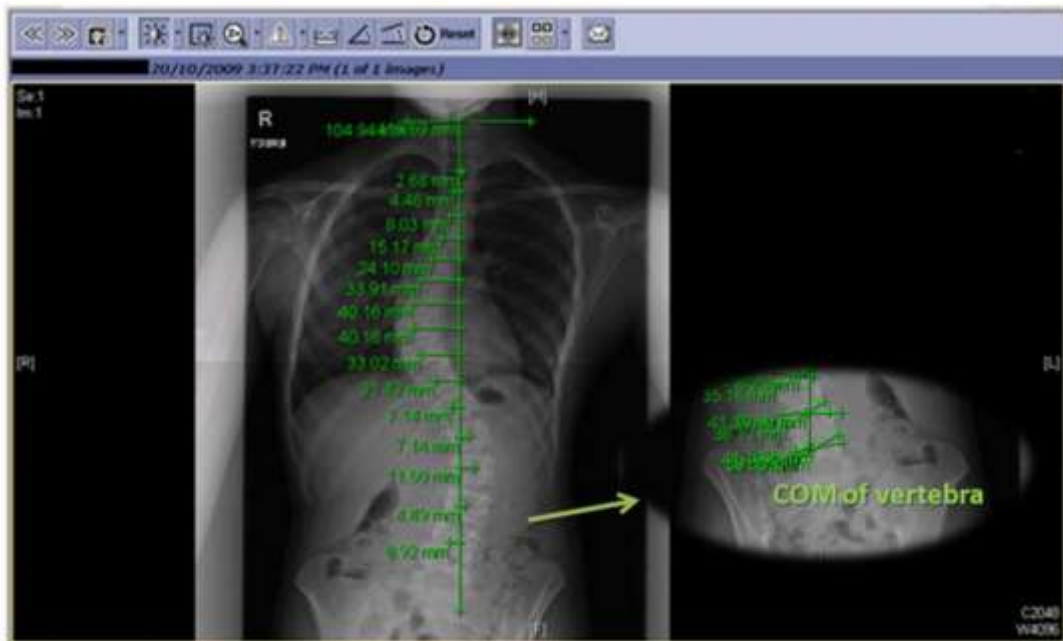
Location of the COM (center of mass) of the vertebrae in X-ray image (Hajizadeh, 2014)
